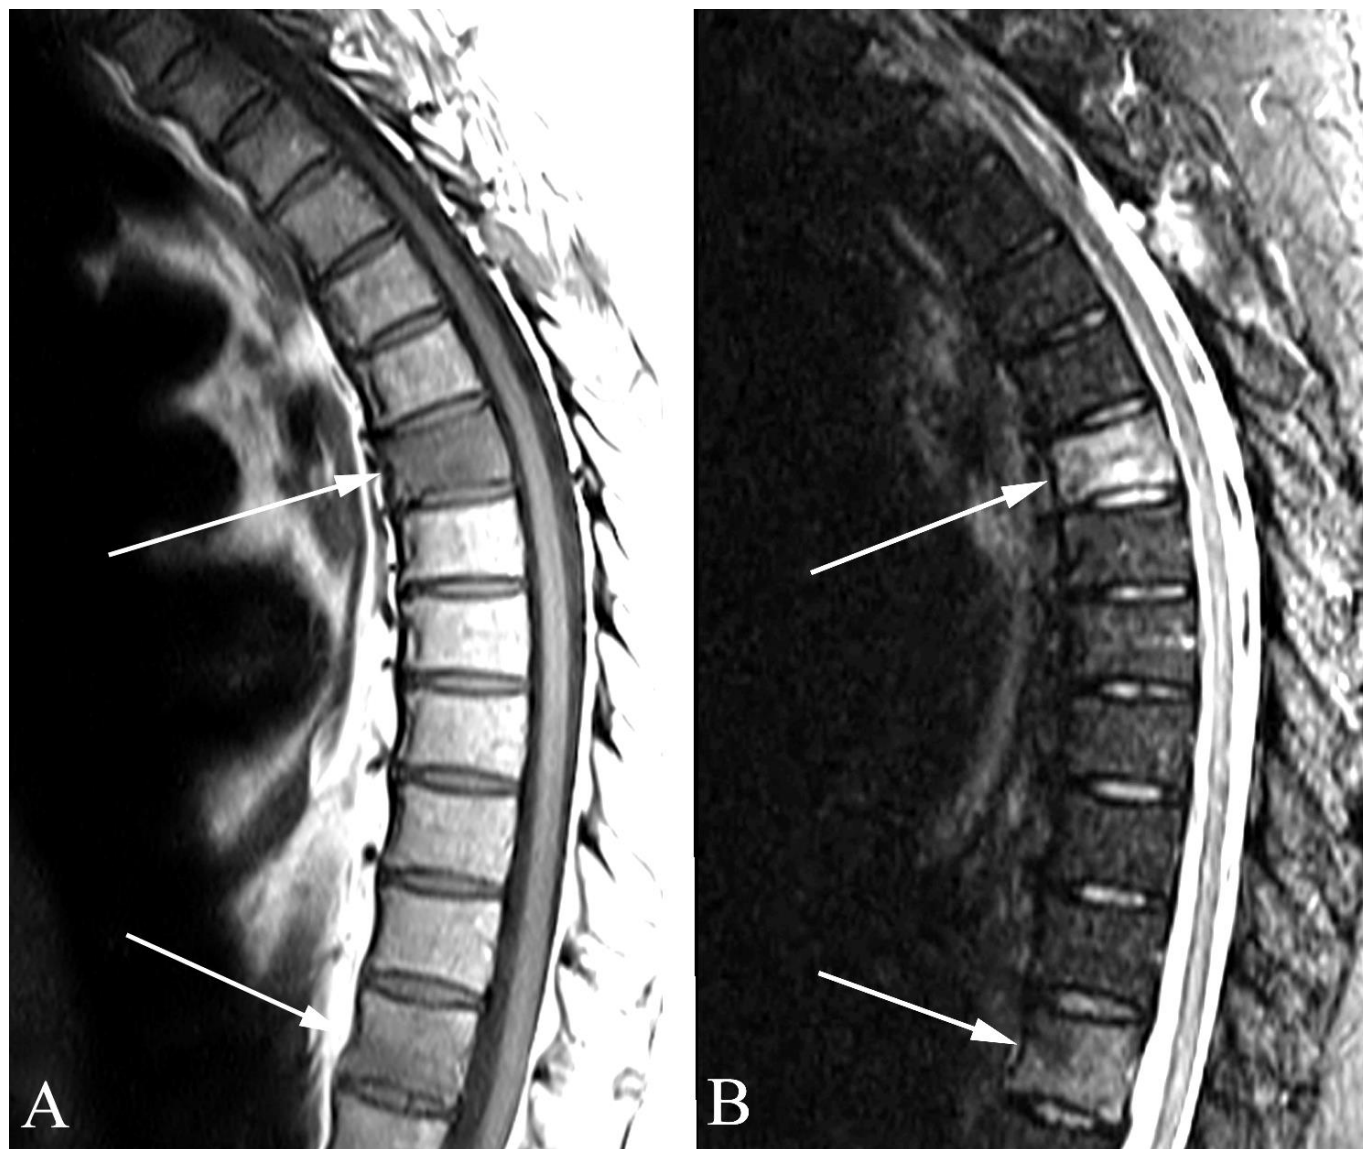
Metastatic lung cancer in a 65 year old man with back pain and known primary malignancy. A. Sagittal thoracic spine T1 weighted MR image shows decreased signal at T6 and T12 (arrows). B. Sagittal thoracic spine fat saturated T2 weighted MR image shows increased signal intensity (arrows), also at T6 and T12.
